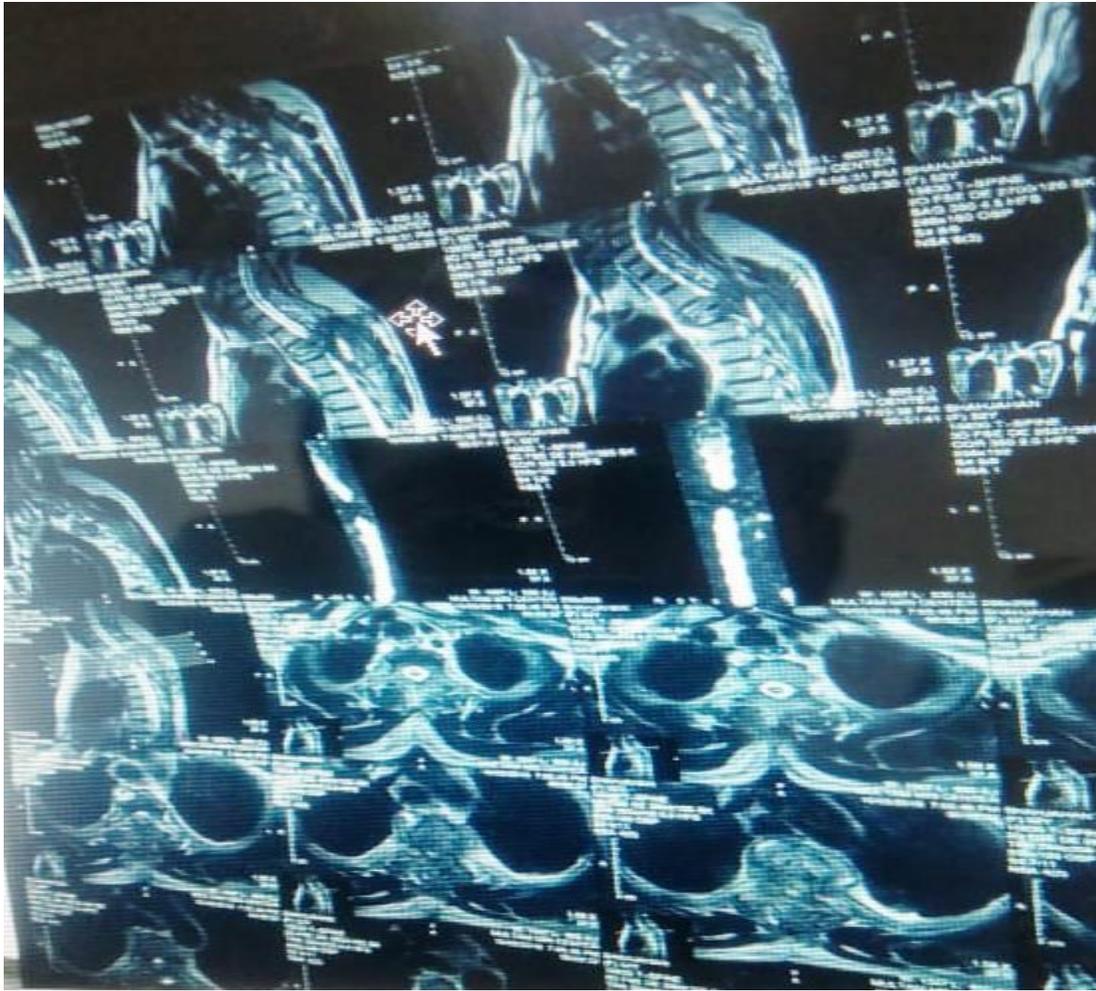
Pre-Operative MRI Thoracic spine.
